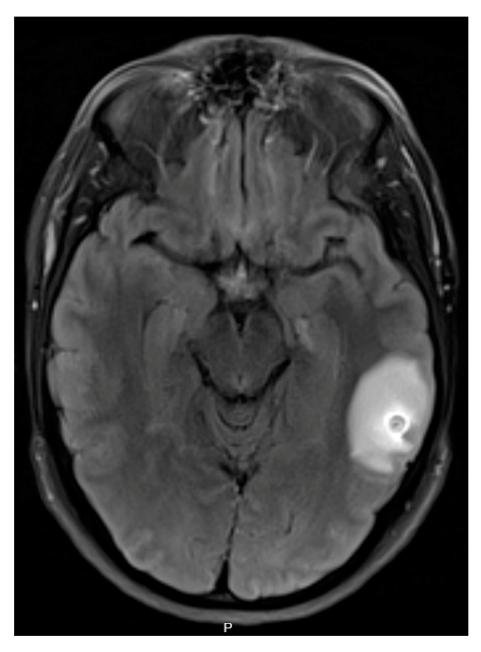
MRI brain, T2–FLAIR, on admission 2023. An 8 mm ring-enhancing lesion within the left temporal-occipital region with regional vasogenic edema, consistent with the colloidal phase of neurocysticercosis.
